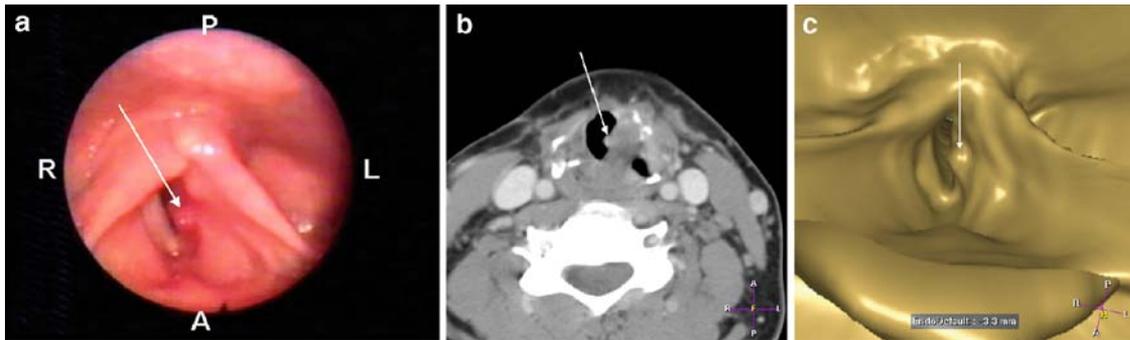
(a) OE image shows a laryngeal tumor (arrow) in a 45-year-old woman involving the left vocal cord with extension into the left supraglottic area and the left aryepiglottic fold. R: right; L: left; A: anterior; P: posterior. (b, c) Transverse CT image through the supraglottic level and VE image showing the tumor (arrow).
